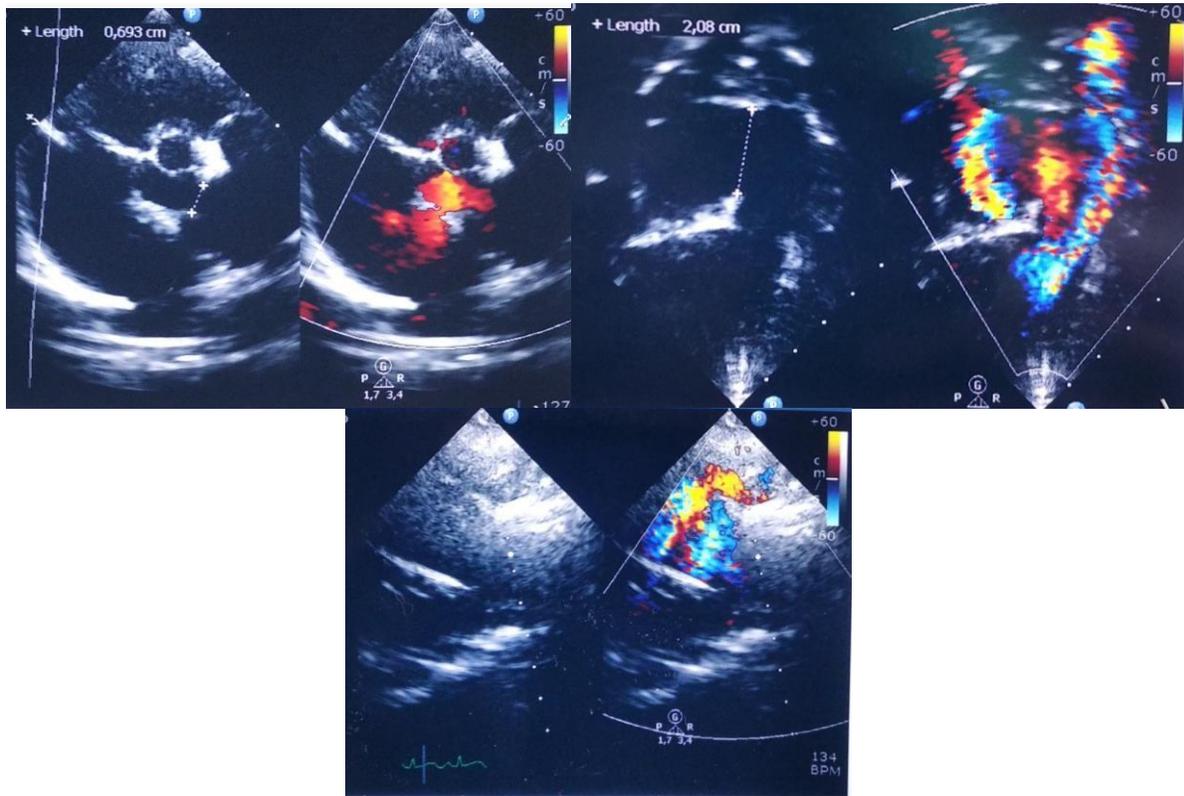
A 4-month-old boy's echocardiography examination shows that IAA associated with PDA (0.69 cm), the other findings is large AP Window (2 cm).
